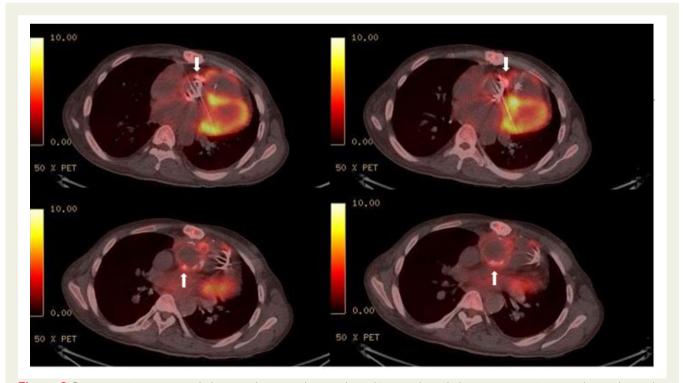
Positron emission tomography/computed tomography scan showed increased metabolic activity in aortic root and around ascending aortic tubular graft indicative of abnormal hypermetabolism (arrow).
